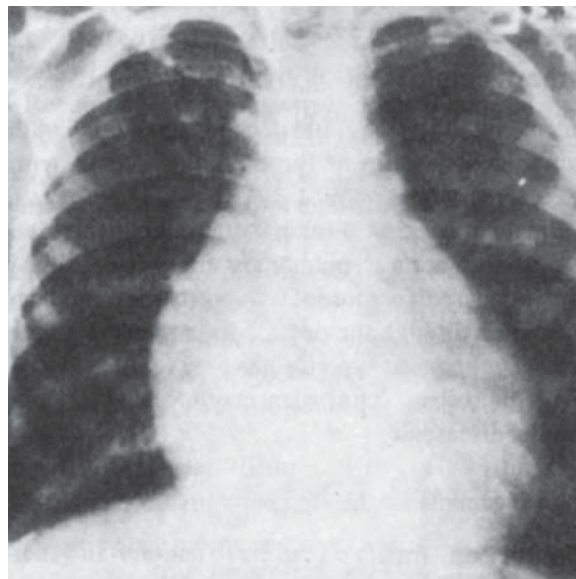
X-ray chest showing cardiomegaly, prominent aortic arch and pulmonary artery in patient with patent ductus arteriosus.
